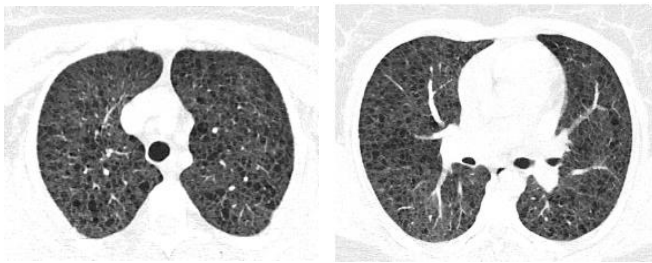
Lung HRCT scan without contrast with diffuse, small, thin-walled lesions
